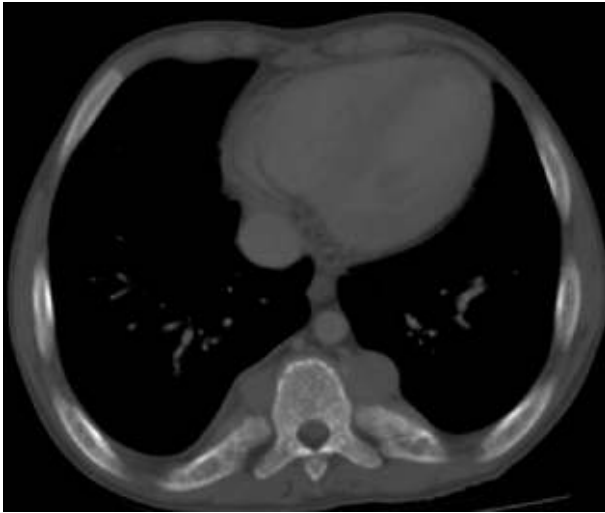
Post contrast CT scan of chest in bone window showing coarse trabeculated expanded ribs with para-vertebral soft tissues bilaterally along dorsal spine suggestive of extramedullary haematopoiesis.
